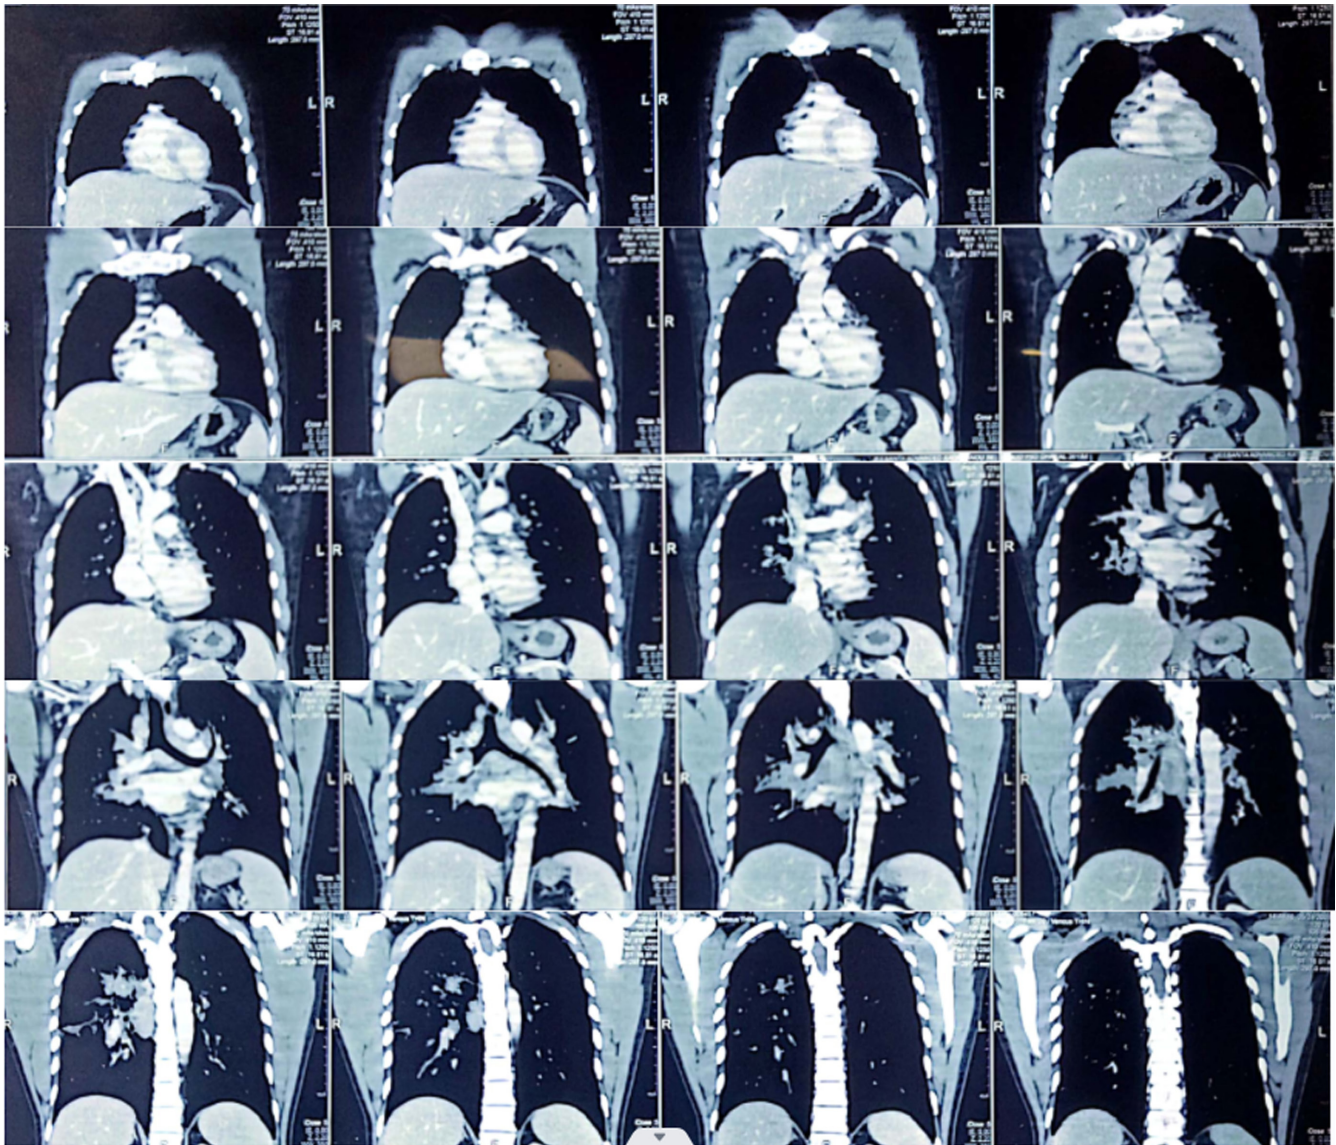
Longitudinal section of Computed Tomography (CT) of the chest revealing discrete opacities in the bilateral perihilar region suggestive of hilar lymphadenopathy.
